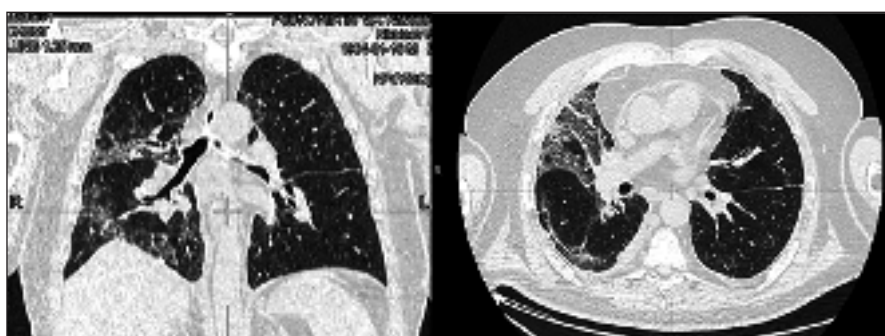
Chest CT of patient N.
